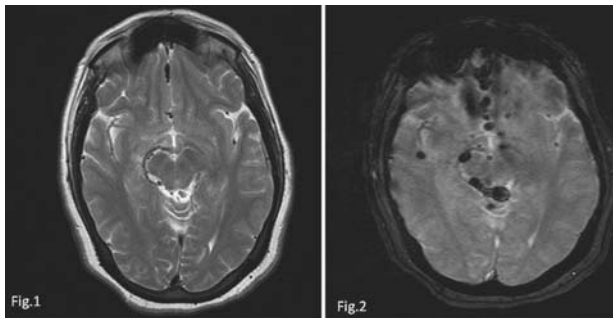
T2-weighted image of brain showing small hypointense foci in the anterior interhemispheric fissure.
